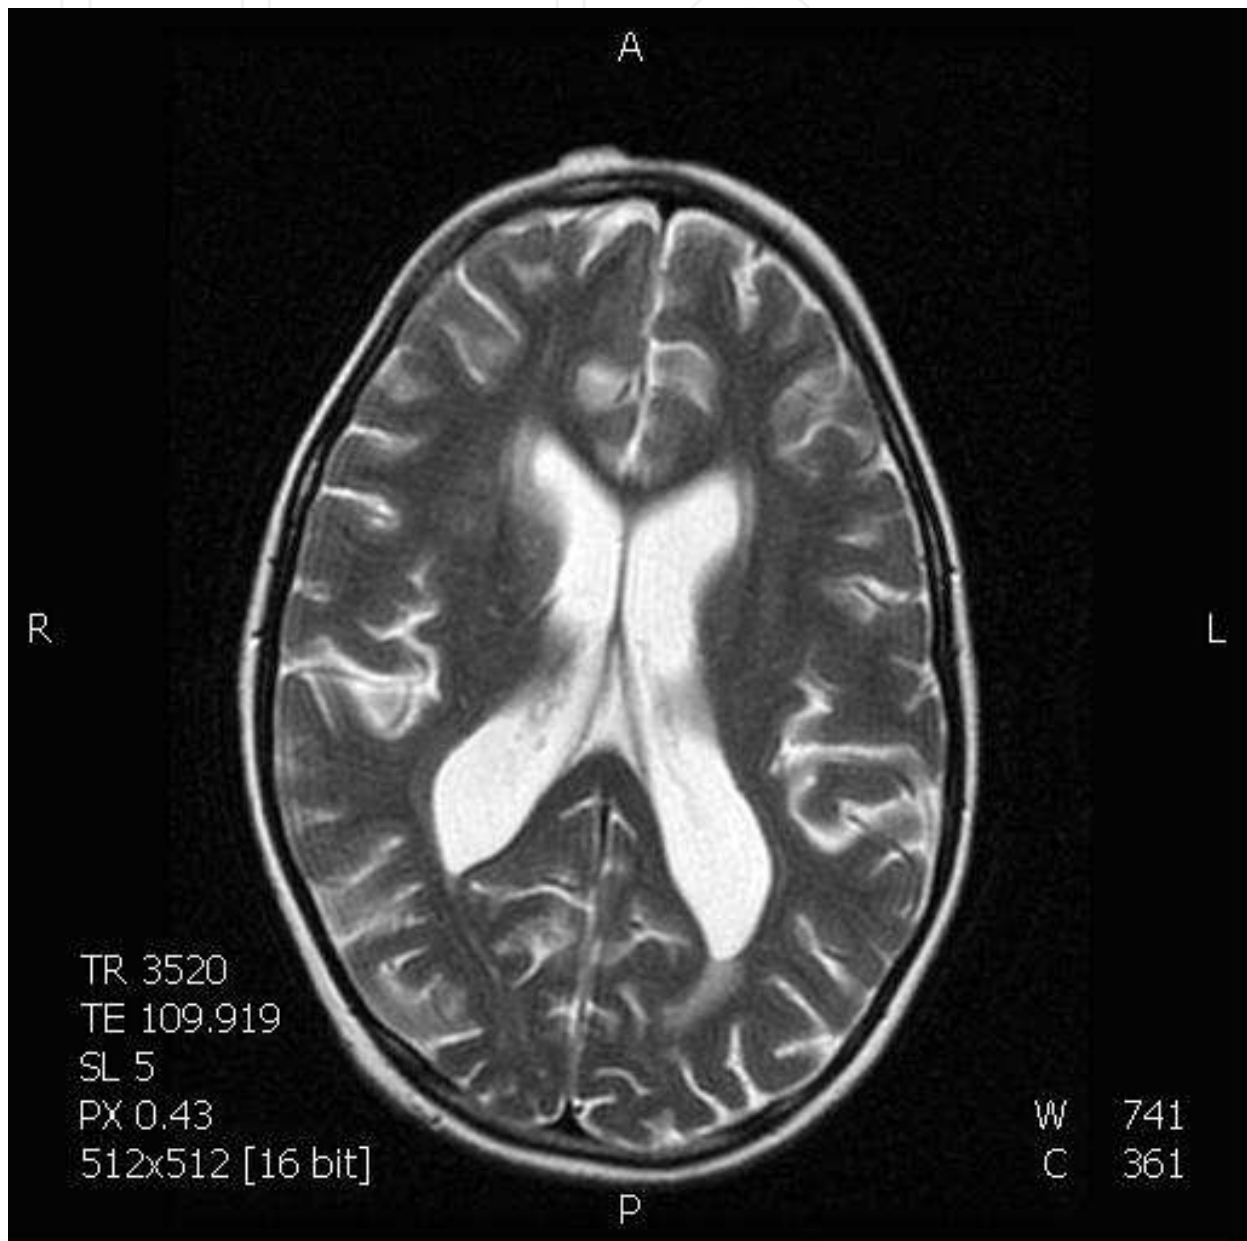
Suprasellar arachnoid cyst: T2-weighted SE image shows a cystic suprasellar lesion which displaces the III ventricle and causes lateral ventricle hydrocephalus.
